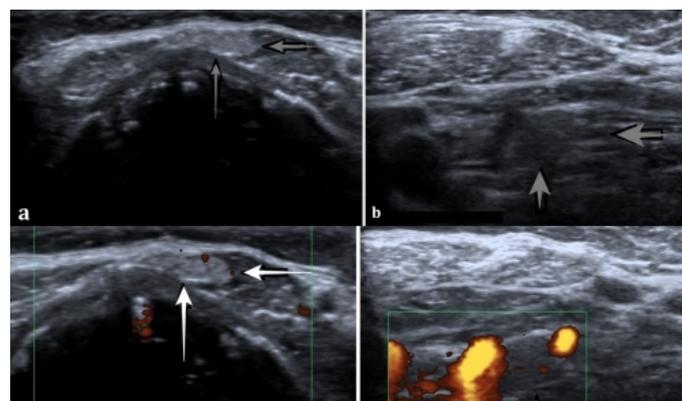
Gray long arrows showing ultrasonography (USG) images of superior (a) and gray short arrows for inferior (b) pyramidal lobes in the right lobe of the thyroid gland; doppler USG images showing the vascularity of superior (c) pyramidal lobe with long white arrows and inferior (d) pyramidal lobes with thick white arrow
